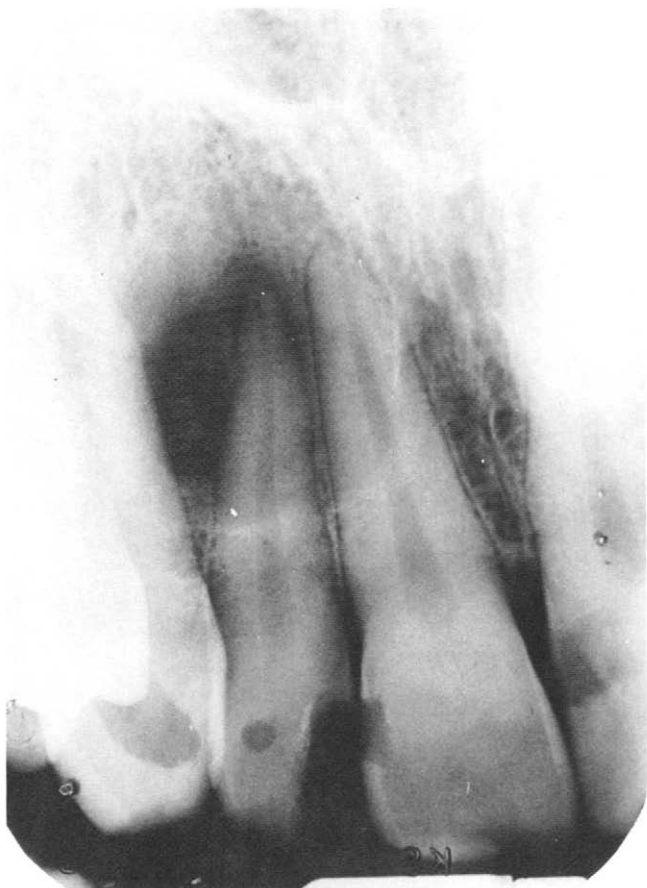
Preoperative radiograph demonstrating periradicular lesion on tooth 7.
